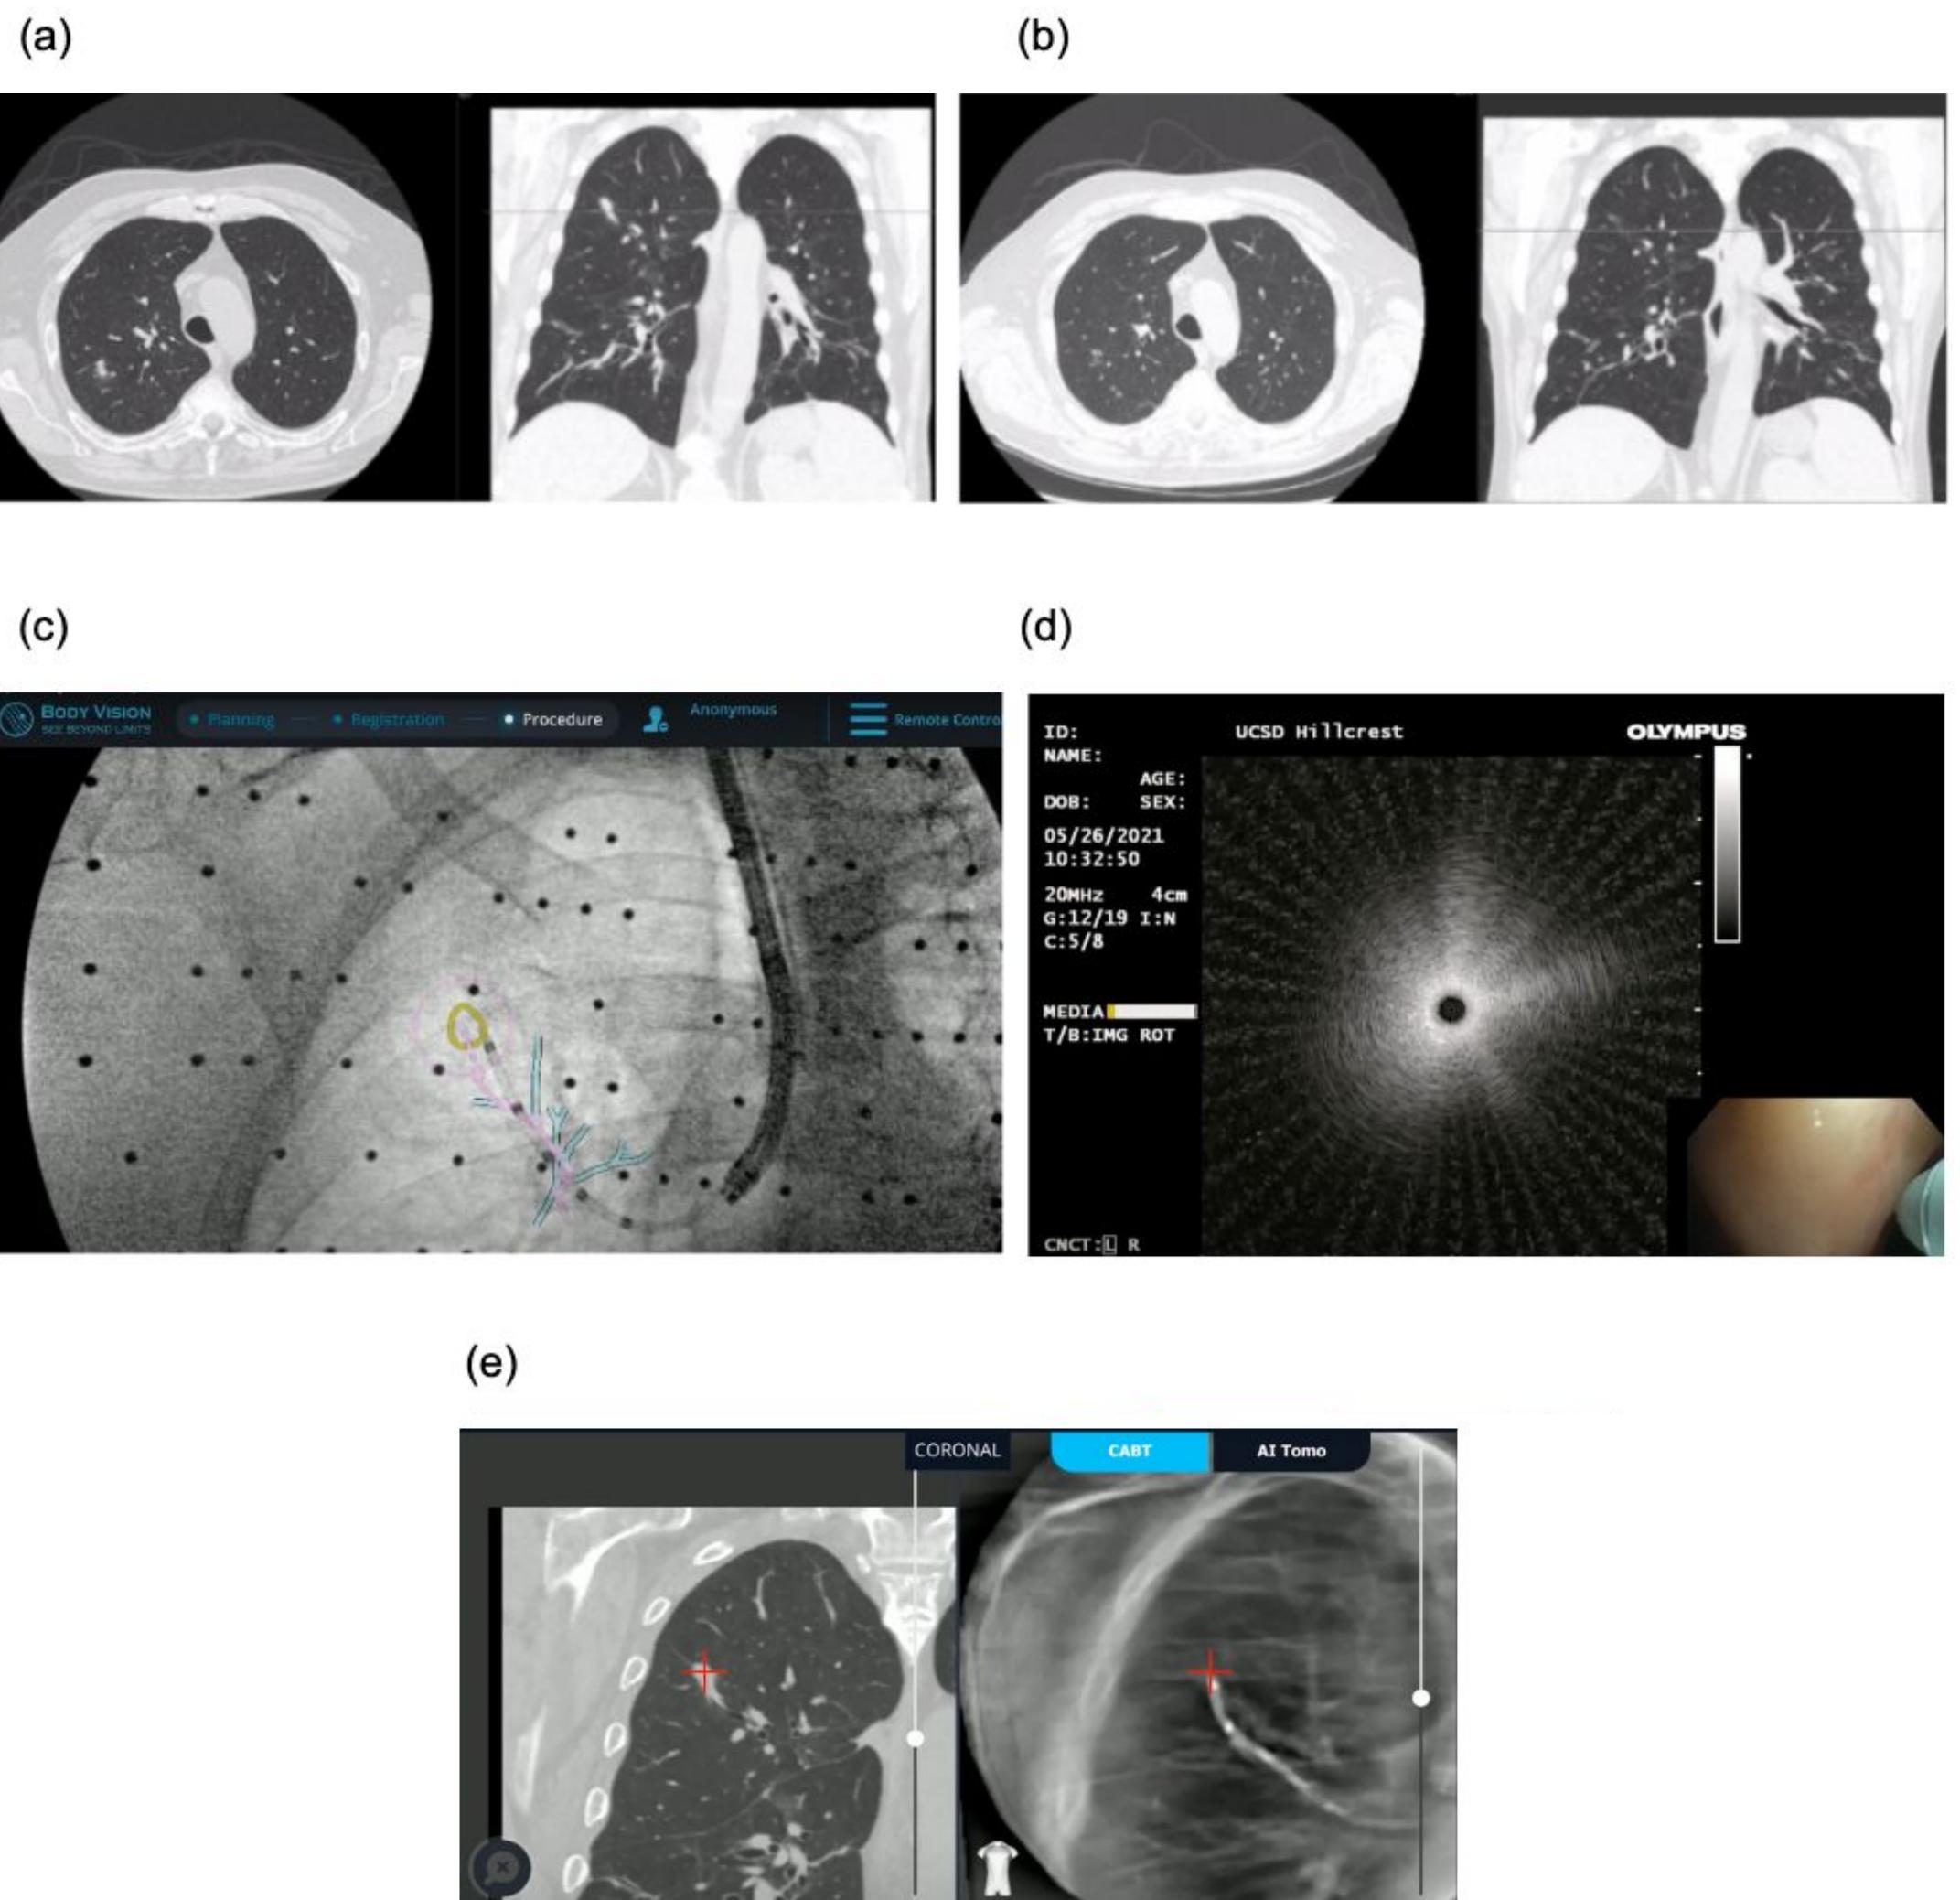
Axial and coronal chest CT ordered in April 2021 (a). Follow-up chest CT in June 2021 showing resolving right upper lung nodule (b). BodyVision 3D construction demonstrating the intended location of the nodule (c). Radial EBUS image during procedure (d). CABT augmented fluoroscopic image showing absent right upper lobe pulmonary nodule on day of procedure (e).
